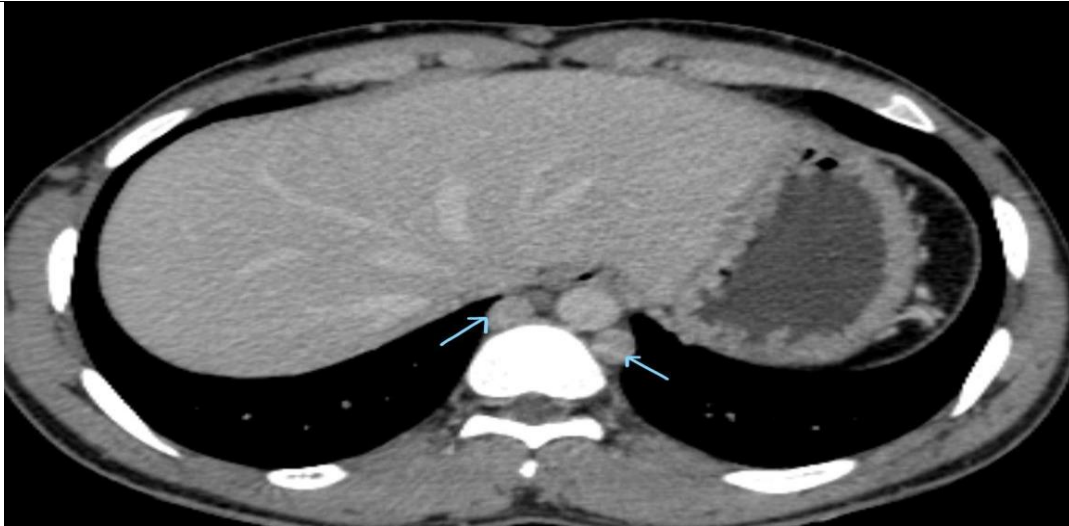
CT Scan Abdomen showing prominent Azygous and Hemiazygous veins (blue arrows)
